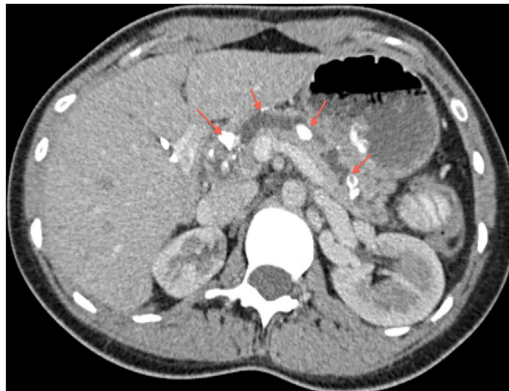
Computed tomography (CT) scan showing multiple calcifications (arrows) in a dilated main pancreatic duct and in side branches.
